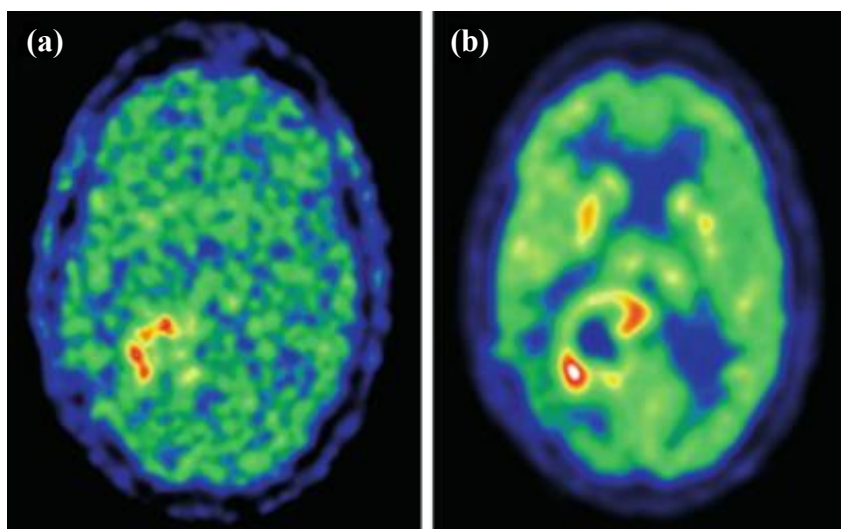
PET imaging of a high-grade glioma wherein the hypoxic regions (red) were assessed by ¹⁸F-FMISO (a) and the high glucose metabolism (red) were determined by ¹⁸F-FDG (b). Note the lack of concordance between the two images, suggesting that a complex relationship exists between the two metabolic processes. Image reproduced from Lee and Scott²⁷⁹.
